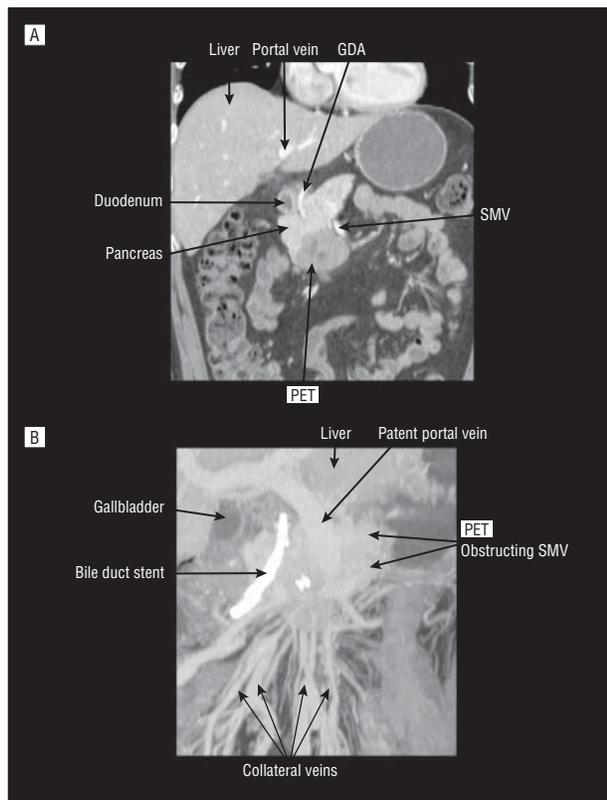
Coronal plane computed tomogram of 2 different pancreatic endocrine tumors (PETs). A, A large tumor is in the uncinate portion of the pancreatic head that is abutting the superior mesenteric vein (SMV). The PET is compressing the SMV and altering its course. The gastroduodenal artery (GDA) is also labeled. B, A locally advanced PET is in the pancreatic head that is obstructing both the SMV and common bile duct. The patient presented with jaundice and had a stent placed in the common bile duct. The PET is blocking the SMV, and one can see extensive collateral veins in the tributaries proximal to the SMV blockage that are returning blood from the gut to the liver.
